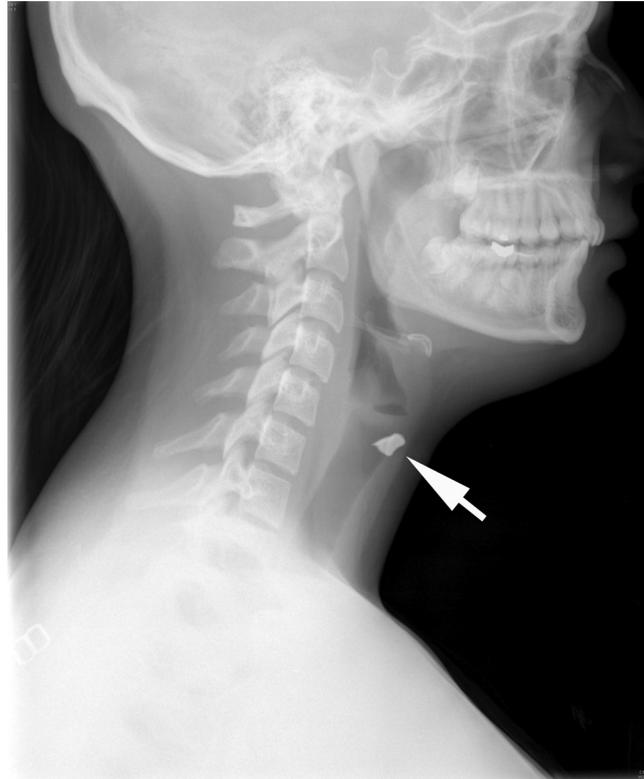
Lateral neck radiograph of a 17-year-old patient shows a large fragment of glass (arrow) embedded in the neck.
